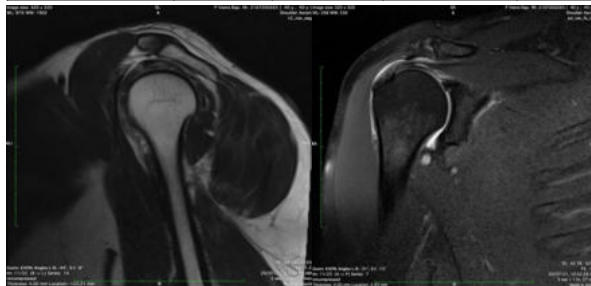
MRI T2 sagittal and PD fatsat coronal images of shoulder joint showing type 2 acromion with partial tear of supraspinatus tendon
